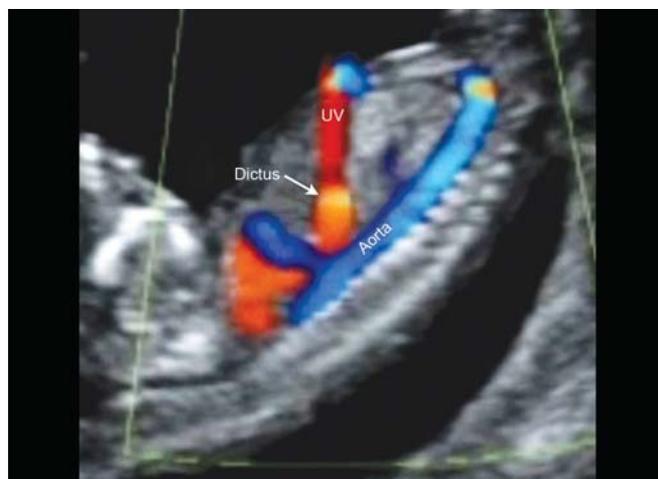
Color Doppler with aliasing representing the turbulence due to the increased velocity in the inlet of the ductus venosus
